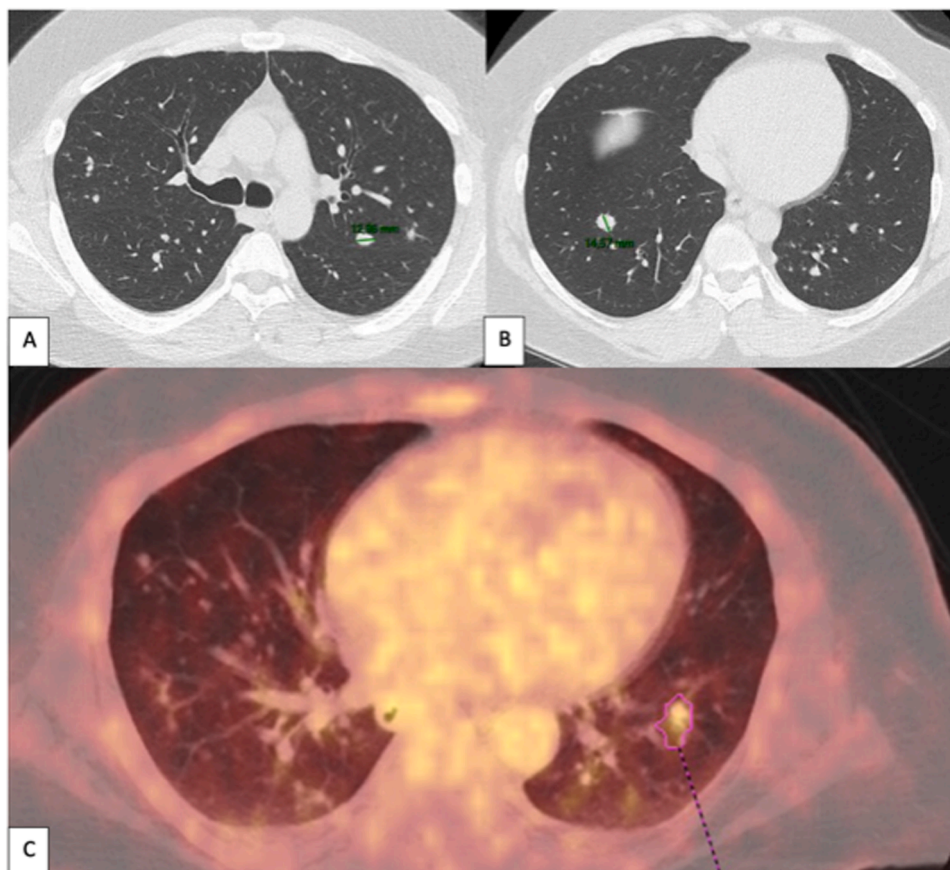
Transverse computed tomography images showing multiple pulmonary nodules (A, B), hypermetabolic on PET scan (C).
